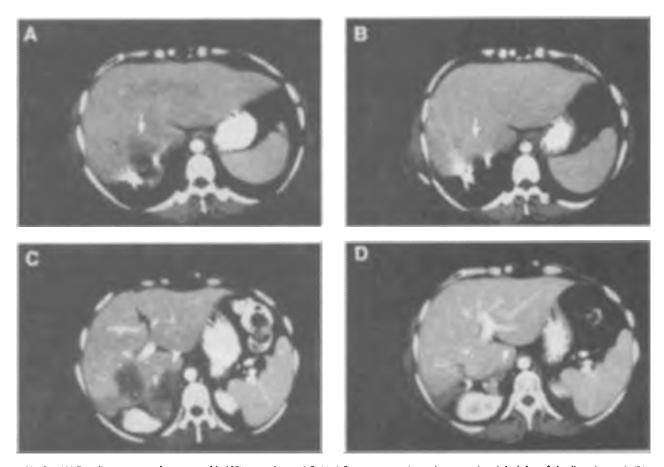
(A) Baseline computed tomographic (CT) scan shows 4.0×4.0 -cm metastasis to the posterior right lobe of the liver (arrow). (B) Follow-up CT scan performed after 2 cycles of CPT-11 shows near total resolution of lesion (arrow). (C) Baseline CT scan demonstrates 5.0×3.0 -cm lesion in lower right lobe of liver (outlined arrow) and 5.0×4.0 -cm metastasis to the right adrenal gland (arrowhead). (D) Near-total resolution of both lesions following 2 cycles of treatment with CPT-11.
